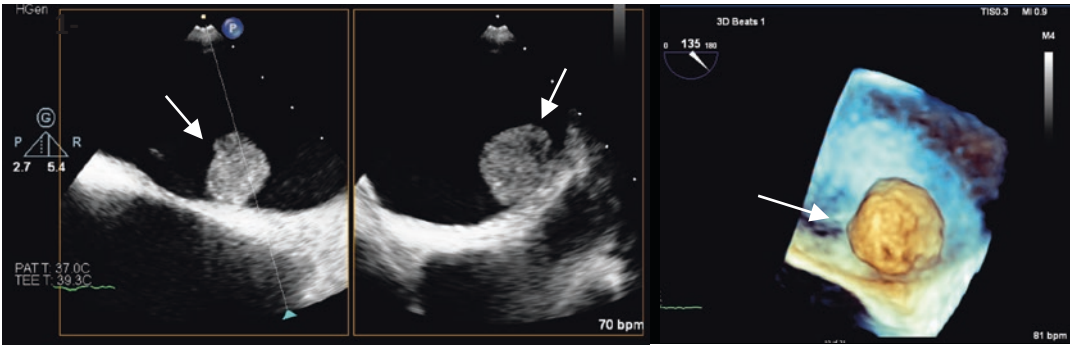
Case 3#: 2D and 3D Transesophageal images showing a 1.5 cm round mass attached to the septum representing an atrial myxoma
